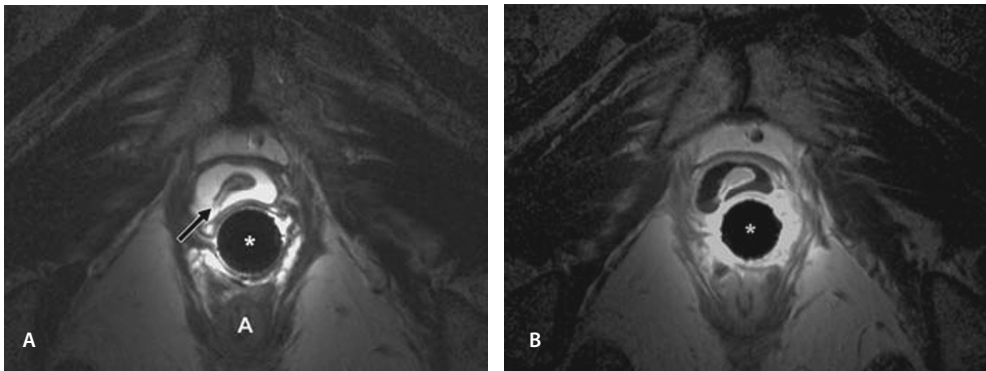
47-year-old-woman with circumferential urethra diverticulum. A, Axial T2-weighted image shows endoluminal coil (asterisk) placement in vagina results in better image quality of urethra and periurethral region compared with Figure 2. Urethral diverticulum with sharp borders, homogeneous hyperintense signal intensity, and identification of ostium in right lower quadrant (arrow) are visualized. A indicates anus. B, Contrast-enhanced axial T1-weighted turbo spinecho image with fat saturation after IV gadolinium chelate administration image obtained at same level as A shows no enhancing components within urethral diverticula. Asterisk indicates endoluminal coil.
